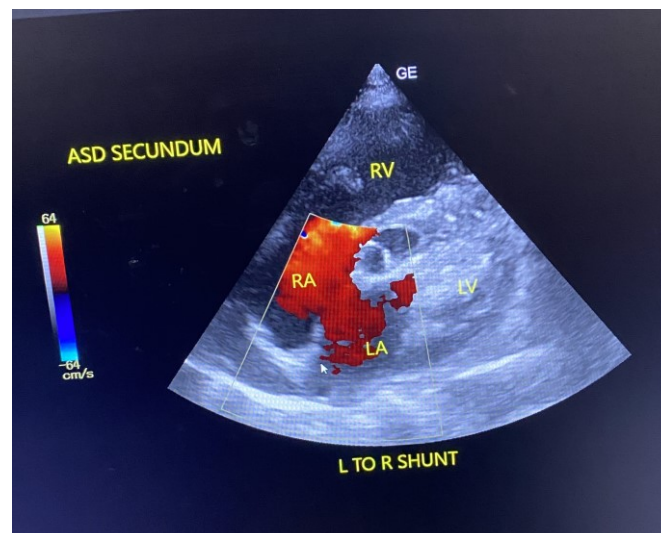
Transthoracic Echocardiography shows ASD Secundum with L to R Shunt
